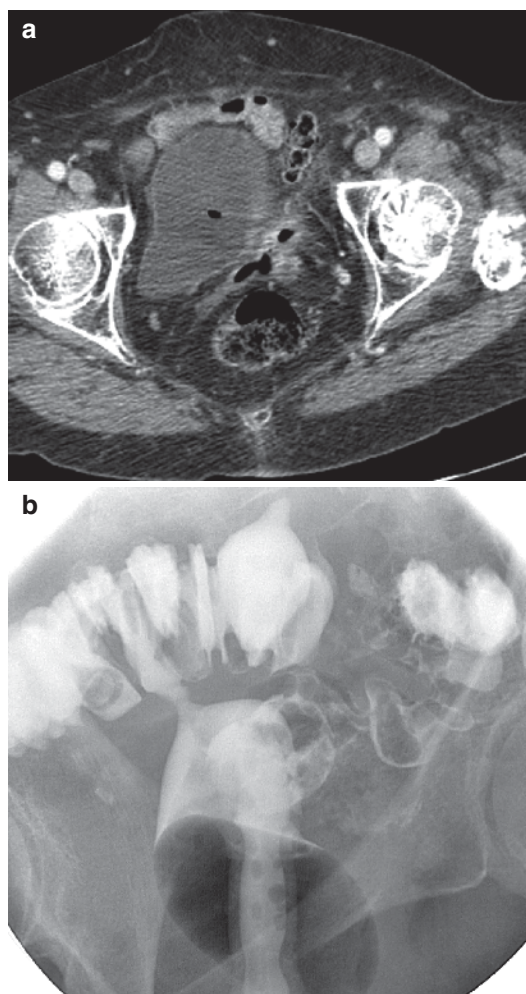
(a–b) A colovaginal fistula is noted on CT with air in the vaginal cuff, inflammation, and fat stranding (a). The fistula is also demonstrated on vaginogram (b).
